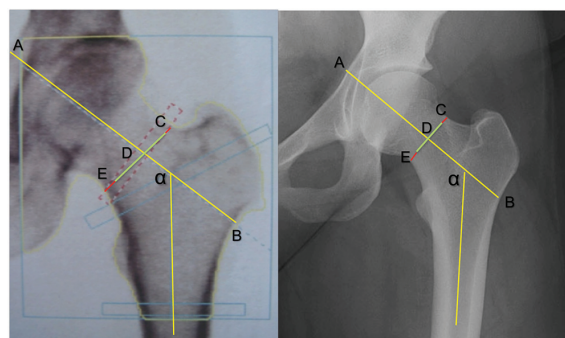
Parameters measured from the hip anteroposterior on a DXA scan (left) and a plain radiograph (right). 1) The distance A to B is the hip axis length, 2) the alpha (α) angle is the femoral neck shaft angle, 3) the distance C + D + E is the femoral neck width, and 4) the distance C plus the distance E is the femoral neck cortical thickness^(14,15).
